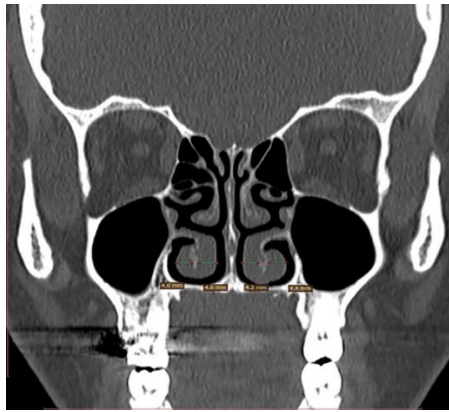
Coronal computed tomography of the inferior turbinate
